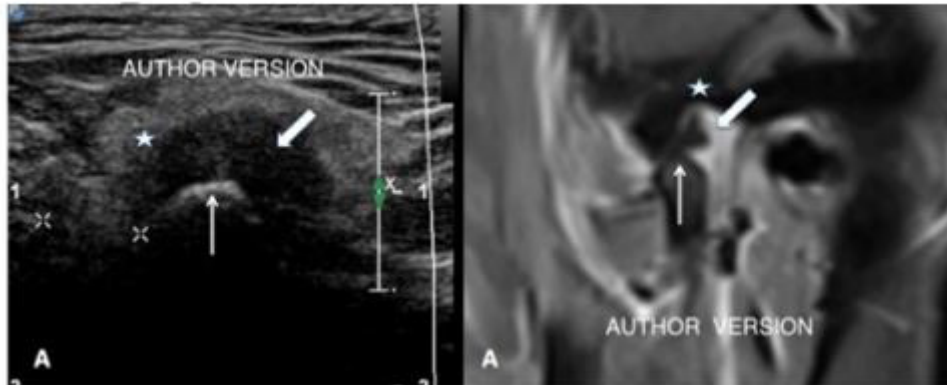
View of exudate causing increased width of the temporomandibular joint gap on ultrasound examination and MRI (star-glenoid fossa, thick arrow-disc, thin arrow-mandible condylar head).
